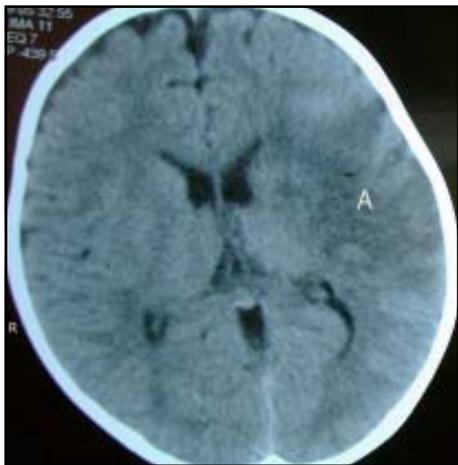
CT scan head showing left capsuloganglionic infarct (A).
